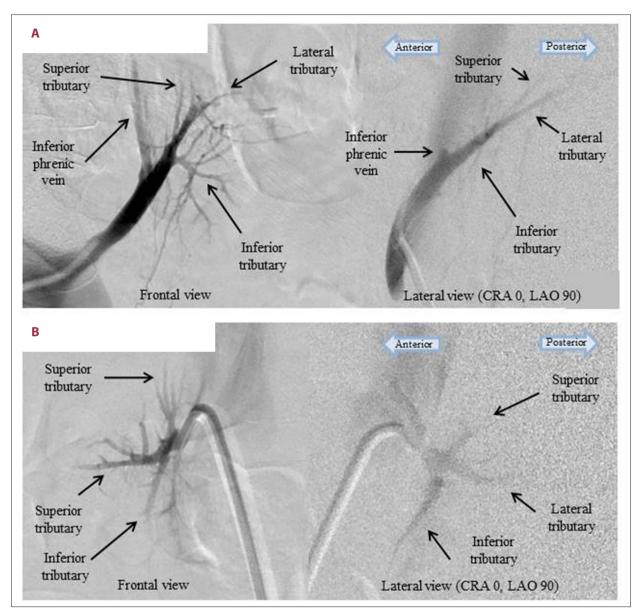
Comparison between the frontal and lateral views during segmental adrenal vein sampling. (A) Left adrenal vein in the frontal and lateral views. (B) Right adrenal vein in the frontal and lateral views. Retrograde contrast enhancement shows the adrenal veins on both sides. Three tributary adrenal veins are clearly seen on both the left and right sides. The mass observed on computed tomography scans is not seen in the left adrenal gland in the angiogram.
